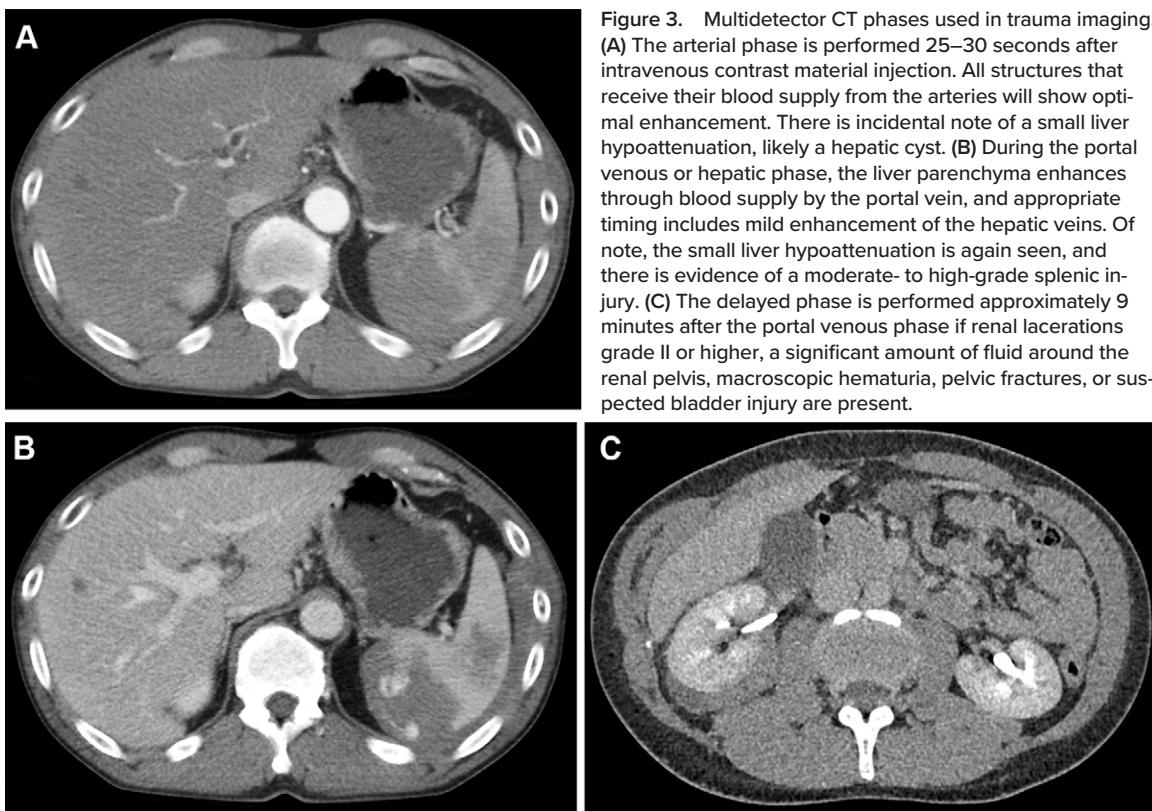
Multidetector CT phases used in trauma imaging. (A) The arterial phase is performed 25–30 seconds after intravenous contrast material injection. All structures that receive their blood supply from the arteries will show optimal enhancement. There is incidental note of a small liver hypoattenuation, likely a hepatic cyst. (B) During the portal venous or hepatic phase, the liver parenchyma enhances through blood supply by the portal vein, and appropriate timing includes mild enhancement of the hepatic veins. Of note, the small liver hypoattenuation is again seen, and there is evidence of a moderate- to high-grade splenic injury. (C) The delayed phase is performed approximately 9 minutes after the portal venous phase if renal lacerations grade II or higher, a significant amount of fluid around the renal pelvis, macroscopic hematuria, pelvic fractures, or suspected bladder injury are present.
